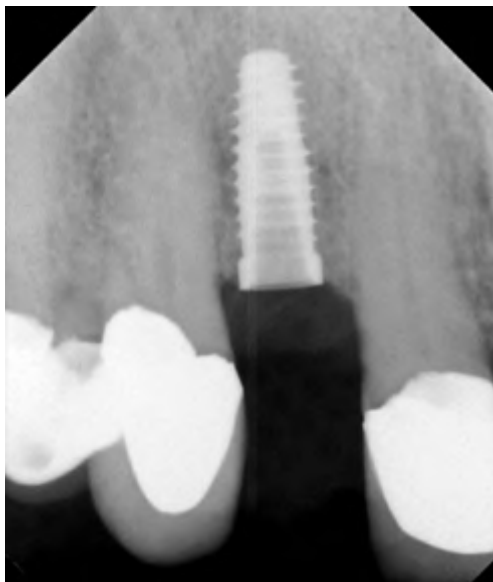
Periapical radiograph of the implant immediately after it was placed into the osteotomy. The periodontist placed the implant at the level of the osseous crest. The implant obtained an insertion torque value of 35 Ncm.
